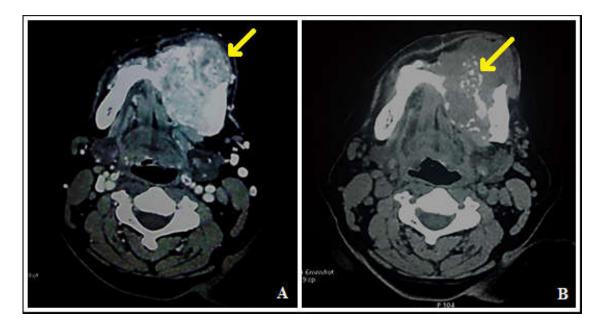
Computed tomography (CT) scan showing mixed osteolytic and osteocondensing density, compartmentalized and the site of multiple calcifications.
